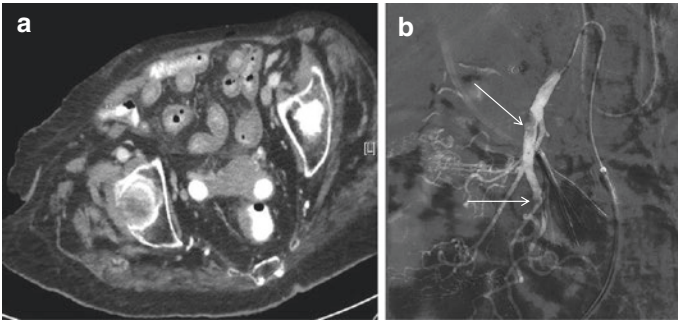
Patient with recent history of hypercoagulable state and pulmonary emboli (after IVC filter insertion) presented with abrupt onset of abdominal pain and lactic acidosis. After initial CTA that showed superior mesenteric artery (SMA) occlusion and thickened small bowel loops (a), a selective angiography shows a nearly occluded SMA secondary to embolus in 2 levels (b, arrows). Thrombolysis was established and resulted in restoration of mesenteric blood flow
